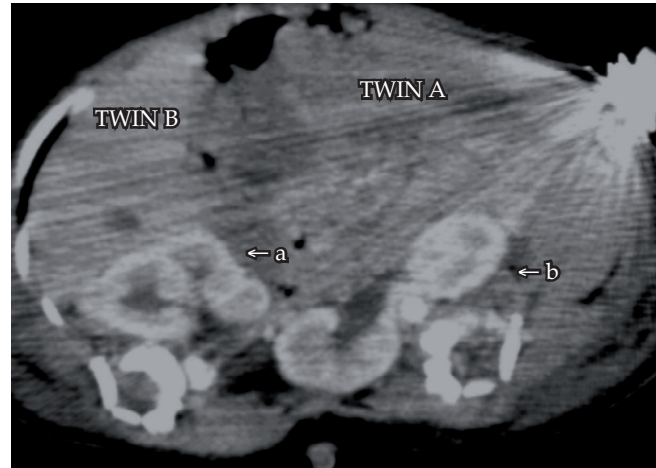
Axial post-contrast CT scan of the abdomen (a = single kidney with a ventral collecting system in twin B; b = central horseshoe kidney with a ventral collecting system in twin A).
